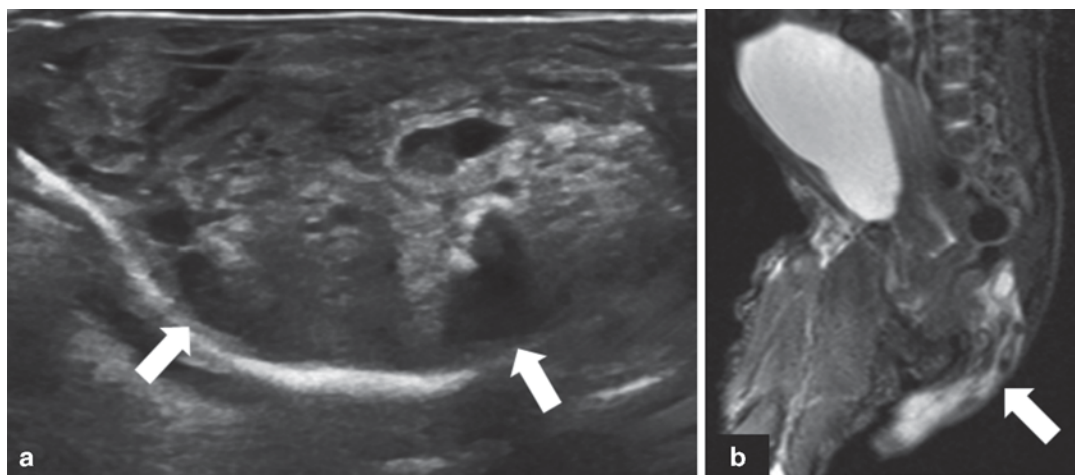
Sacrococcygeal teratoma. Sagittal ultrasound image (a) and sagittal MRI T2-weighted (b) of the perineal region. Exophytic, heterogeneous mass with solid
